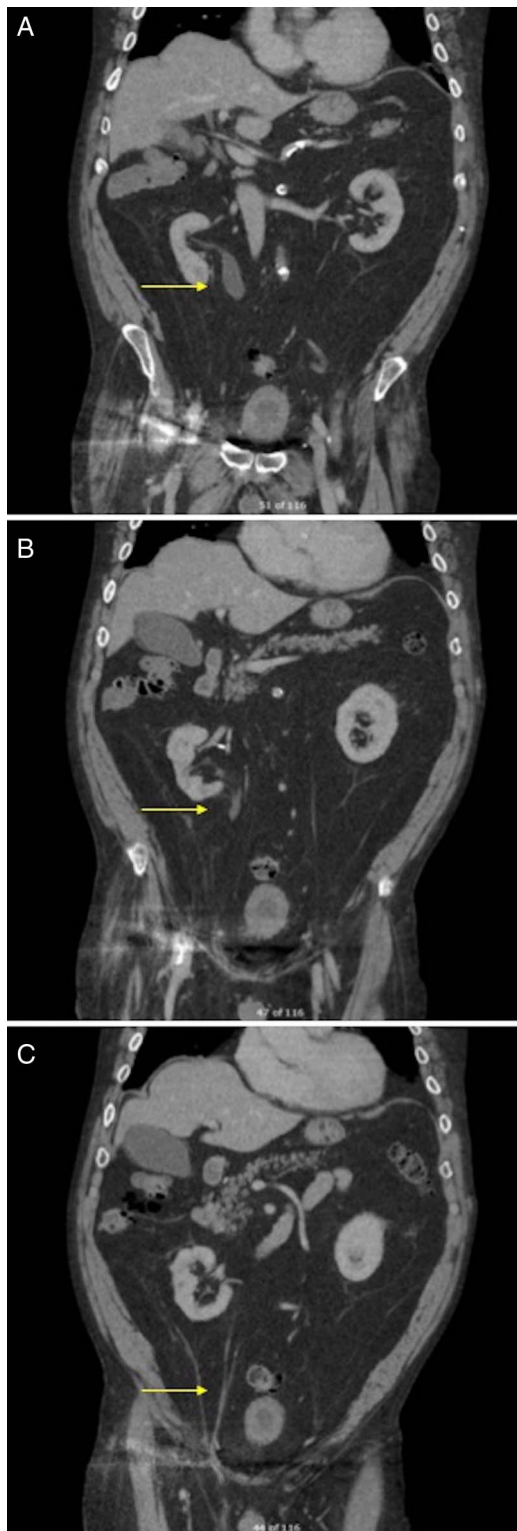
Computed Tomography (CT) intravenous pyelogram showing a partially dilated right ureter extending down towards a right inguinal hernia (arrow).
